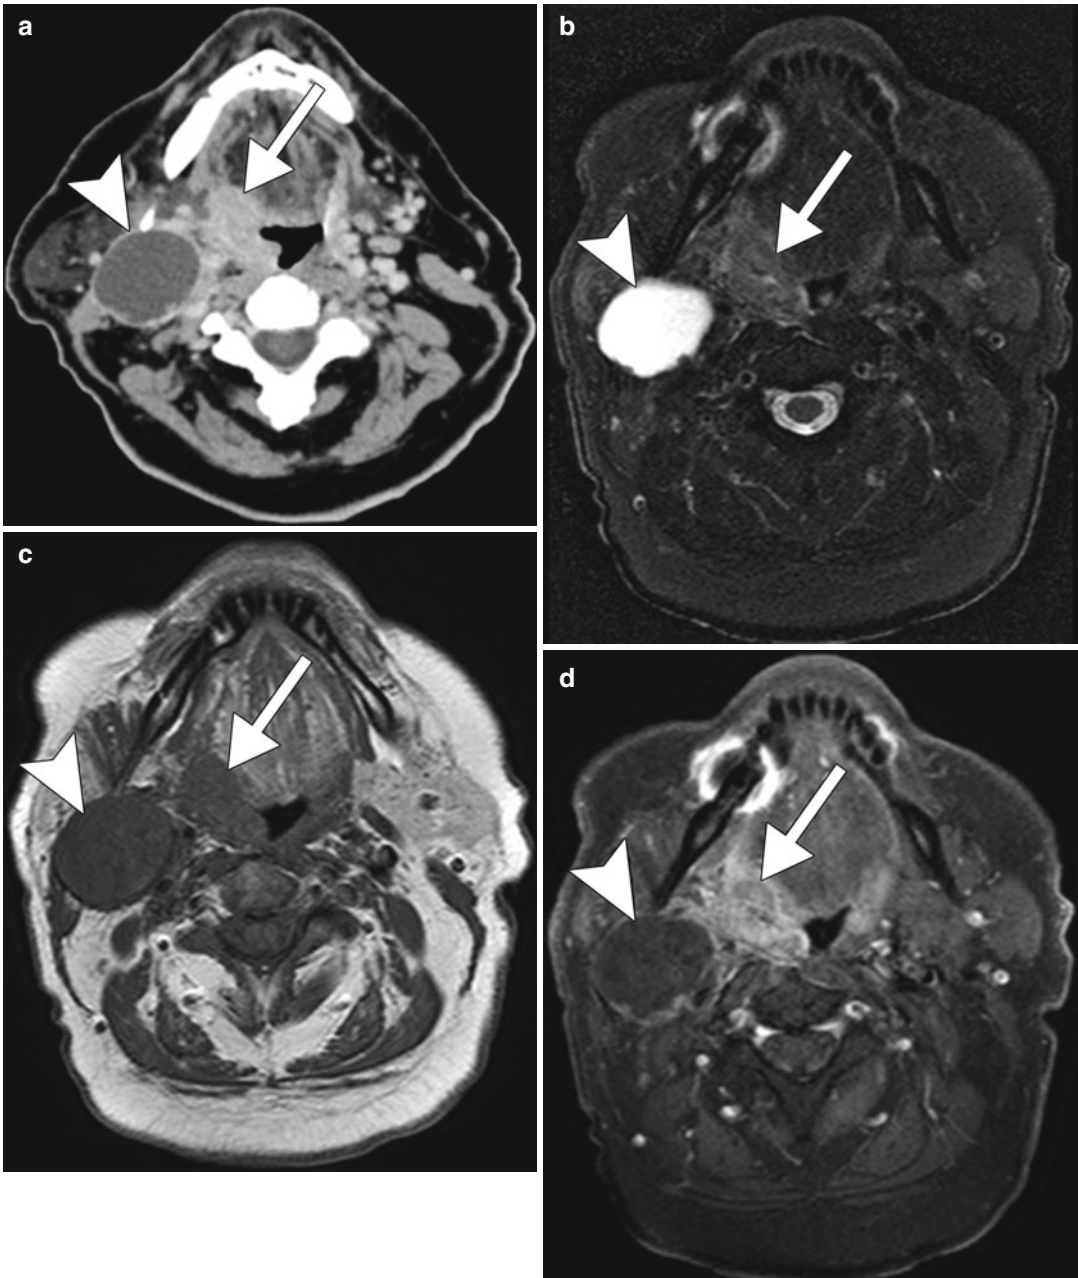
HPV-positive squamous cell carcinoma. Axial CT (a) and axial fat-suppressed T2-weighted (b), axial T1-weighted (c), and axial fat-suppressed post-contrast
